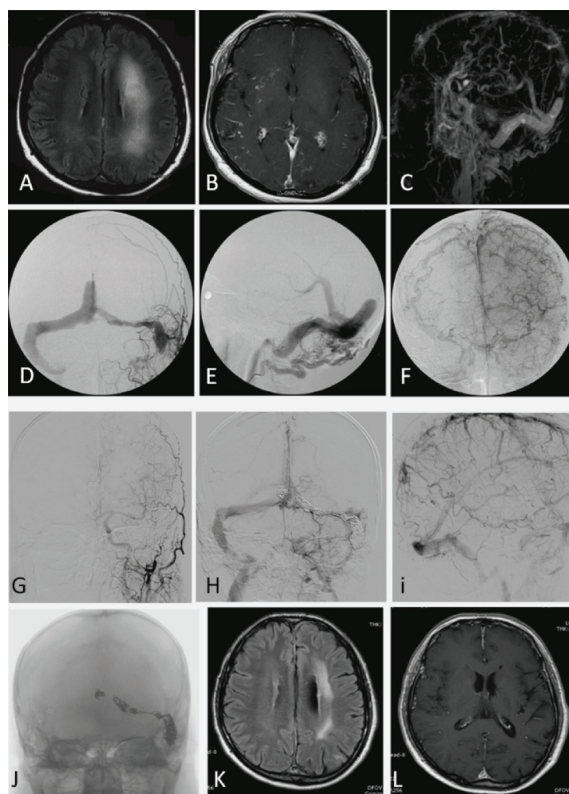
A 49 year old man had progressive right sided weakness with deteriorated cognitive function, ataxia and blur vision. (A-C) MRI and MRA before treatment showed white matter change with malignant cortical reflux. (D-F) The angiogram revealed left sigmoid sinus thrombosis and dural AV shunts with retrograded drainage into superior sagittal sinus, right transverse sigmoid sinus with cortical reflux (Cognard IIa+b) resulting in venous congestion and severe white matter change, particularly on the left side. The patient had successful complete closure of the dural AV shunt by both transvenous coiling and transarterial glue embolization. The angiogram showed re-functional of posterior 1/3 of superior sagittal sinus without venous congestion (G-I). Although the clinical outcome was favorable, and the patient had complete recovery, the MRI still showed white matter changes at 4 years follow-up (J-L).
